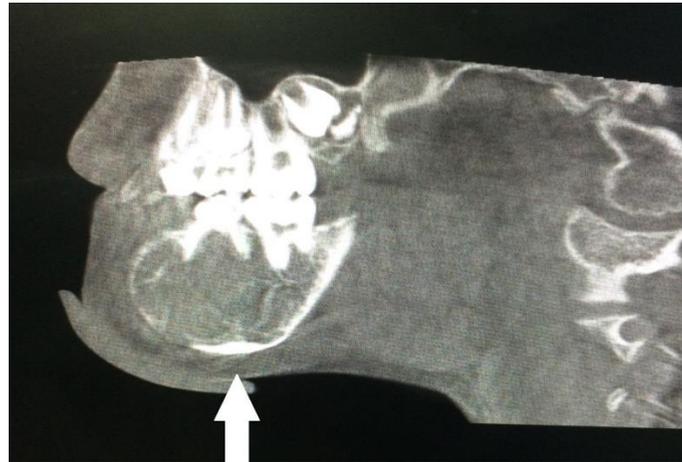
CBCT view (Coronal Section)
